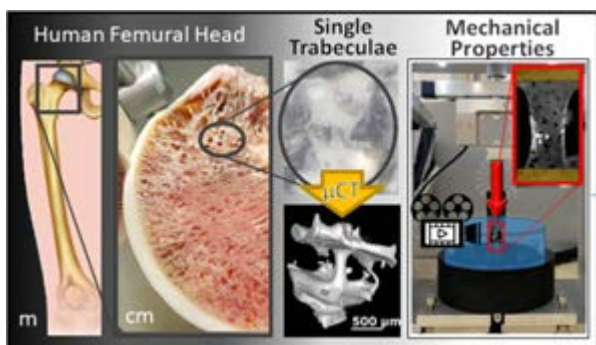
Trabeculae were extracted from a human femoral head and imaged via μ CT. The speckle pattern was tracked using a video camera. Mechanical properties were assessed in compression.
